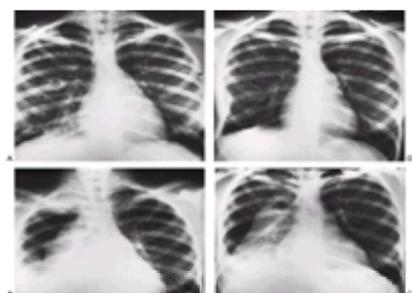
Serial chest roentgenograms taken during a 6-month period in an 18-year-old girl with pelvic inflammatory disease demonstrate multiple metastatic lung abscesses caused by *Bacteroides* and microaerophilic streptococci (A) and paravertebral empyema (B) with gas formation (C), which eventually resolved following drainage (D). Note multiple abscesses (*arrows*, A.)
